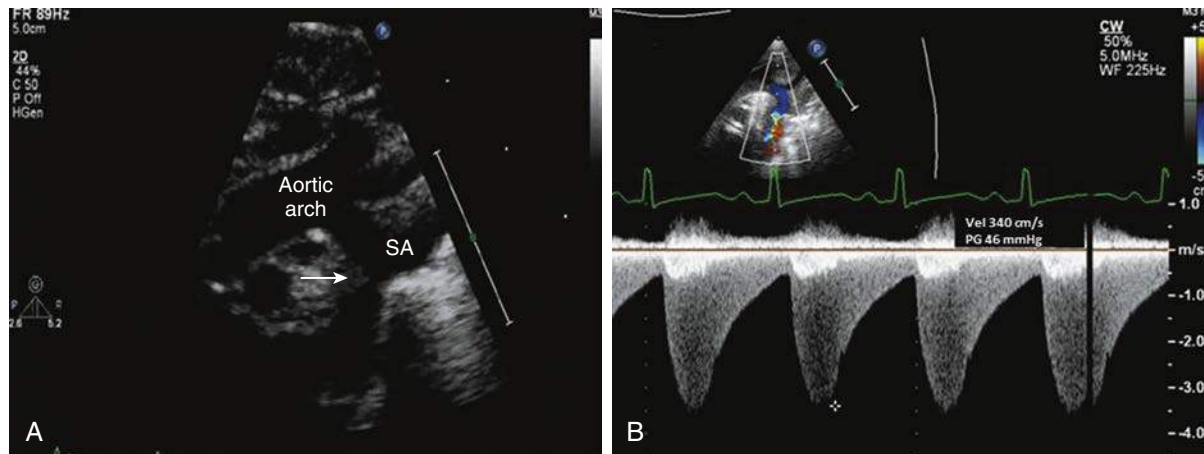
A, Coarctation of aorta (CoA). Two-dimensional transthoracic echocardiography (2D TTE) suprasternal view of the aortic arch. A discrete narrowing is seen distal to the SA (white arrow). B, Continuous-wave (CW) Doppler recording through the CoA in the descending aorta. Note the high peak systolic flow velocity with a long diastolic tail characteristic of significant CoA. SA, Subclavian artery.
